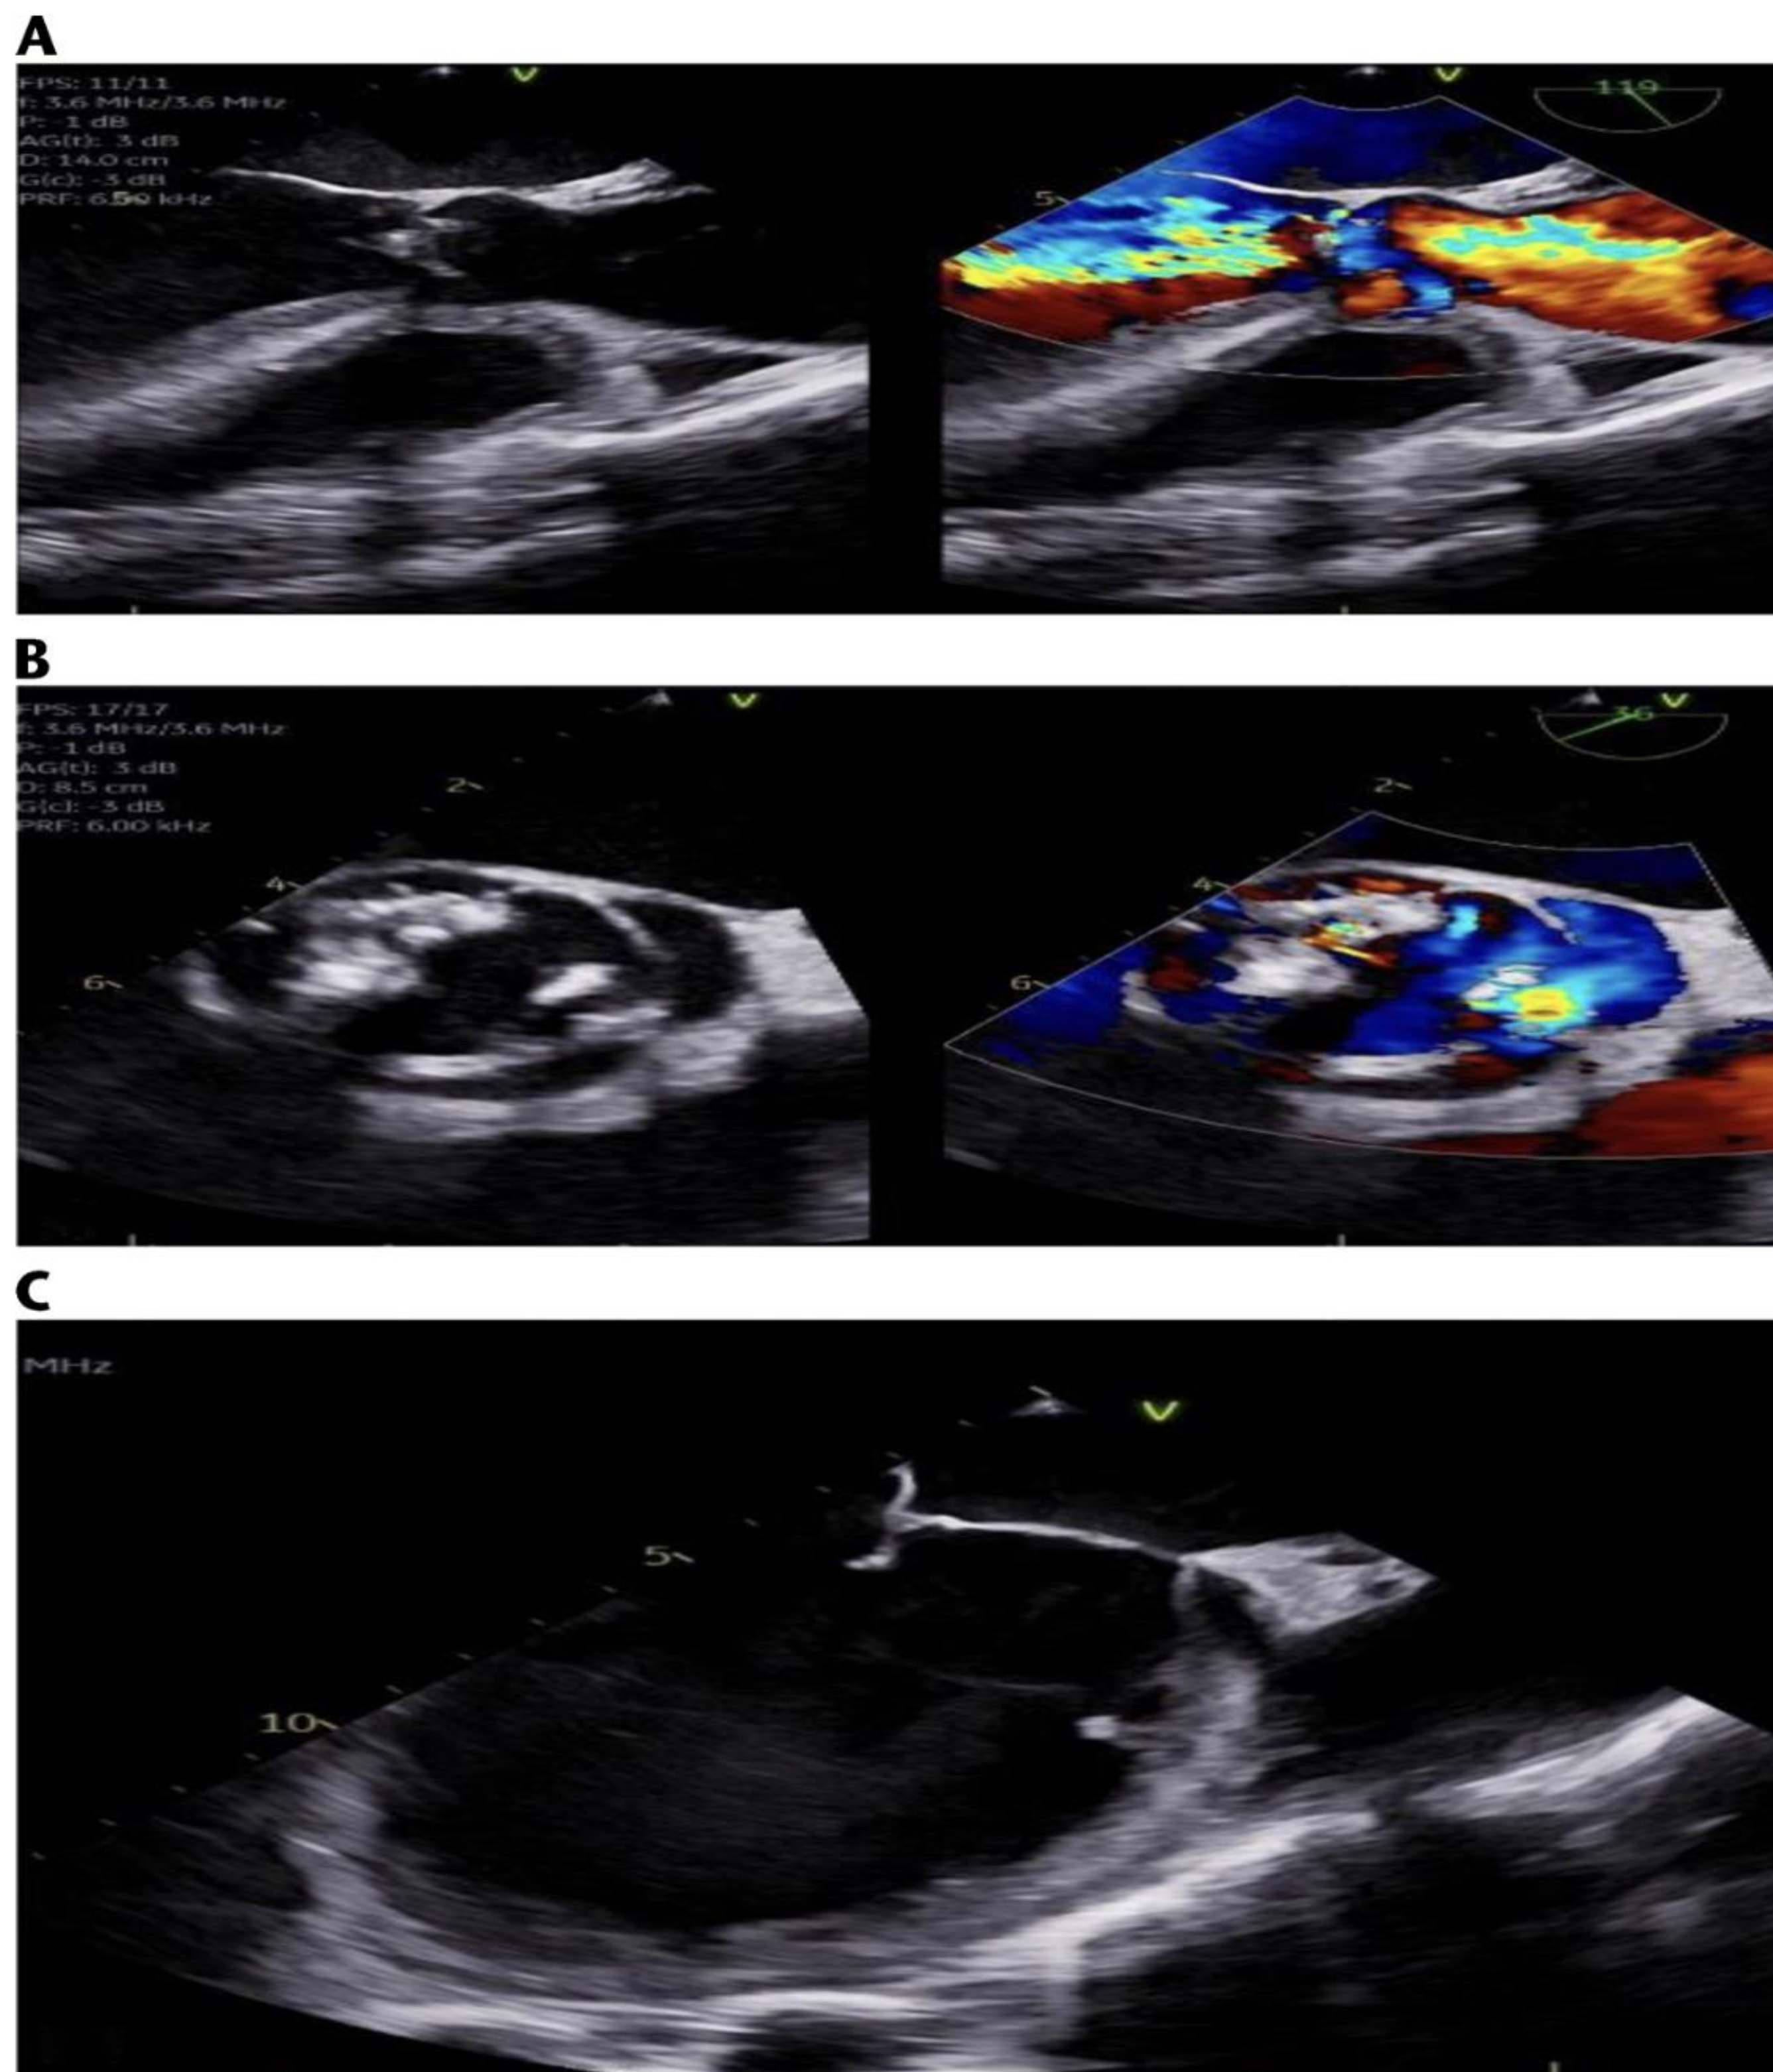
Transesophageal echocardiogram showing a bicuspid aortic valve with moderate to large mobile vegetation adherent to the noncoronary cusp and smaller mobile vegetation adherent to the left noncoronary cusp with associated severe aortic regurgitation (A, long axis; B, short axis). A small mobile vegetation adherent to the anterior mitral leaflet (C).
